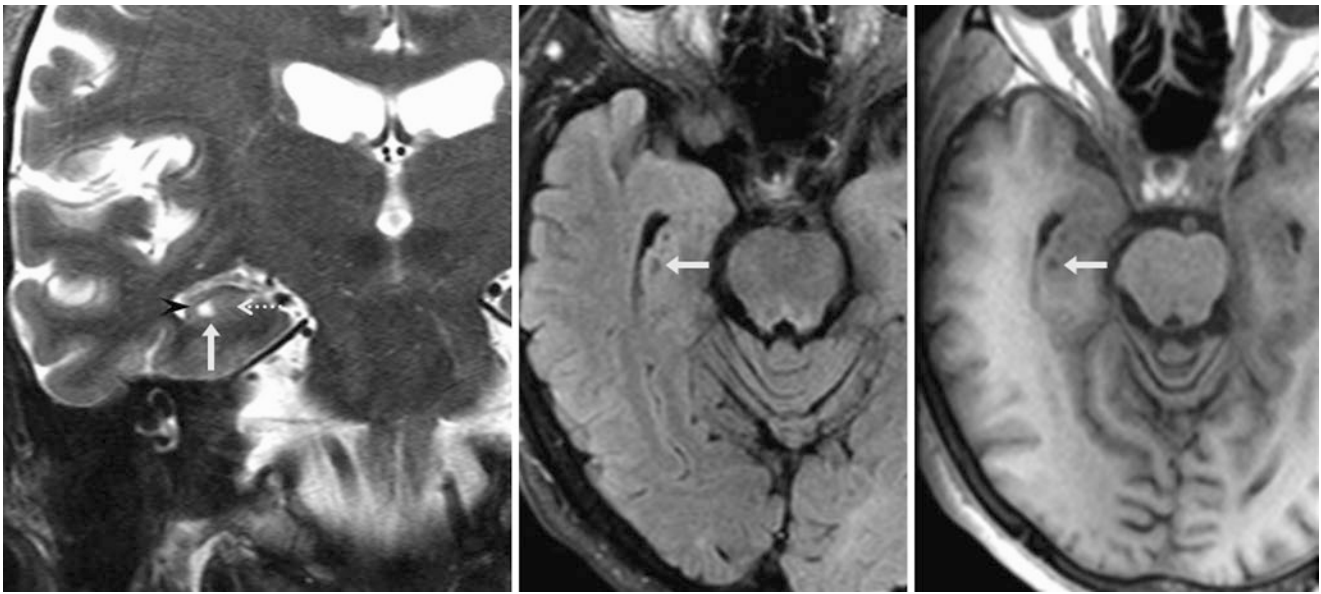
A 68 year old had a 3 T MRI that showed a right hippocampal cyst (arrows), which may represent a remnant hippocampal sulcus. On coronal T2WI (left), note the hippocampus' cornu ammonis laterally (black arrowhead) and the dentate gyrus medially (dotted arrow). The cyst is similar to CSF on FLAIR (middle) and T1WI (right)
